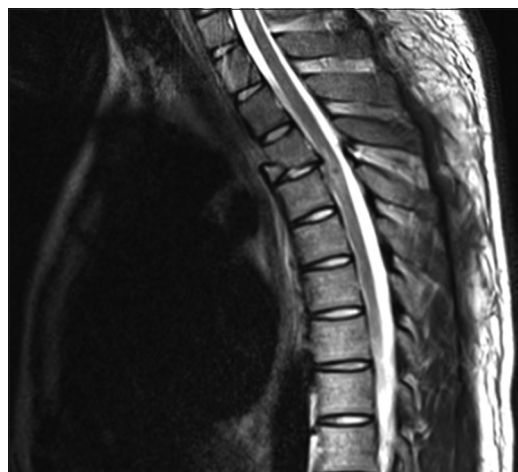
T2-weighted MRI sagittal section of the thoracic spine showing D3 teardrop fracture with impingement of the adjacent spinal cord by the posterior fragment.
